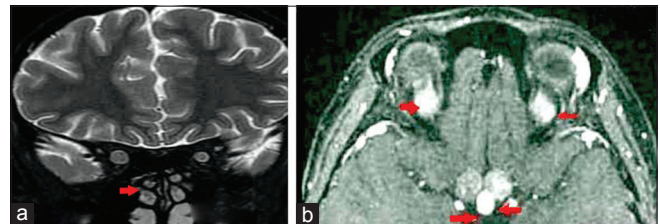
(a) Repeat magnetic resonance imaging – coronal cut showing bulky chiasm and thickened infundibulum; (b) magnetic resonance imaging brain and orbits with gadolinium contrast axial cut showing moderate increase in severity of bilateral optic nerves and optic chiasm signal intensities and thickening with prominent and nodular anterior lobe of pituitary gland
